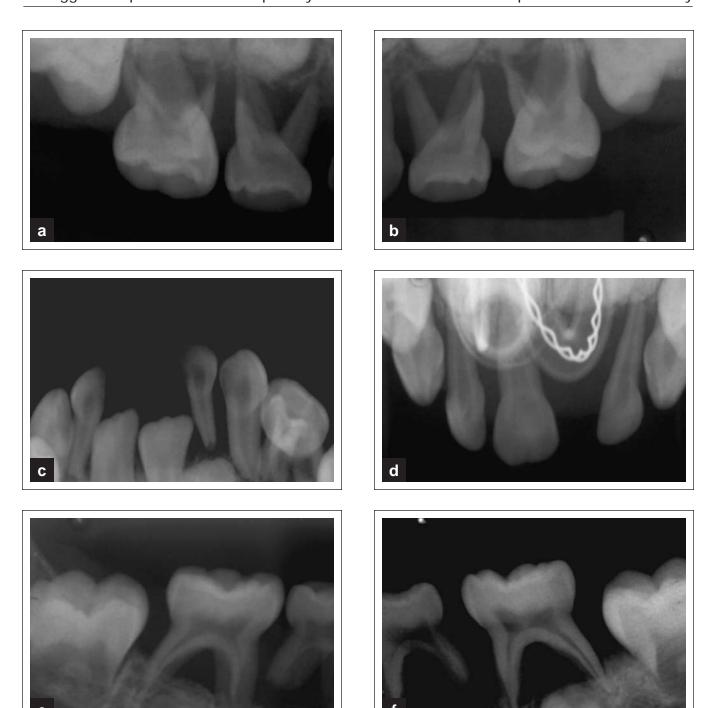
Radiographs of a child with aggressive periodontitis in the primary dentition related to immune deficiency. Severe alveolar bone loss is evident in all quadrants.
